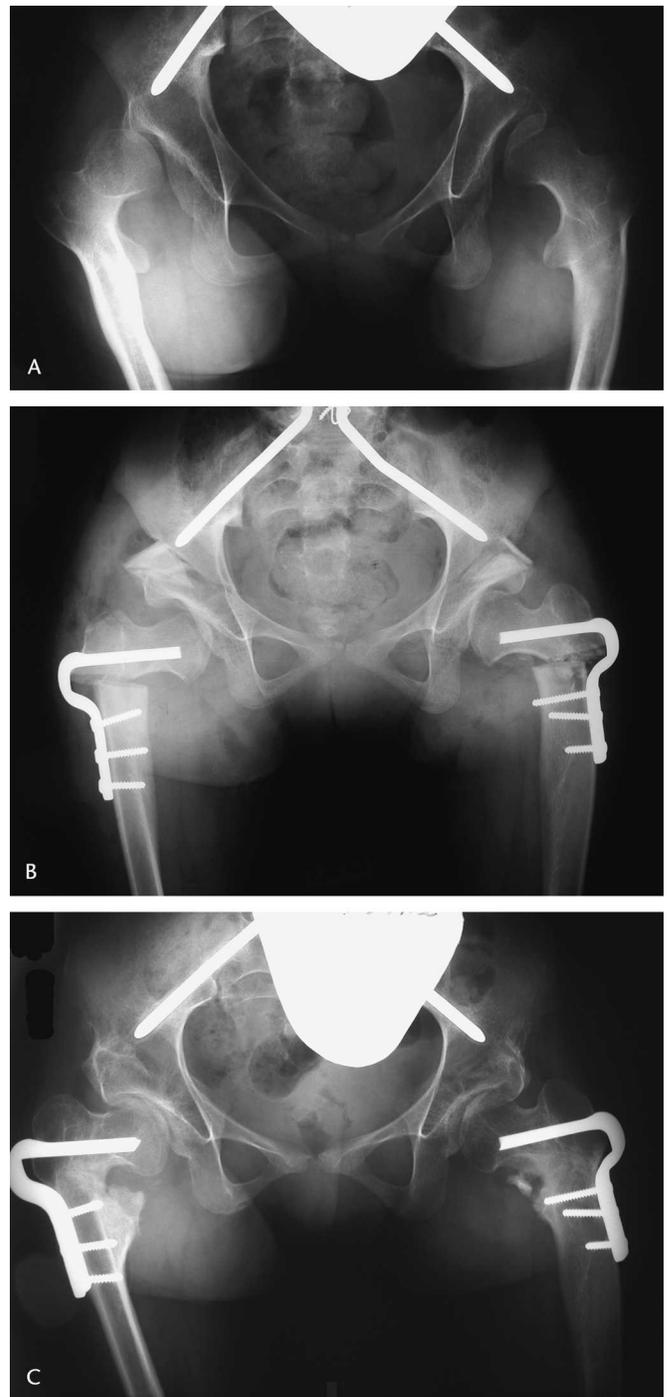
(A) A preoperative anteroposterior radiograph shows the pelvis of a 14-year-old nonambulatory patient (Case 19/20) with painful acquired spastic hip disease. The triradiate cartilage is completely closed. (B) An immediate postoperative anteroposterior radiograph shows bilateral proximal femoral VDROs in conjunction with bilateral incomplete transiliac osteotomies. No internal fixation was necessary to secure the pelvic allograft. (C) A followup anteroposterior radiograph was obtained 7 years postoperatively. Despite moderate limitation of hip motion, the patient remained pain-free and had an excellent overall result with no restriction of sitting tolerance.
